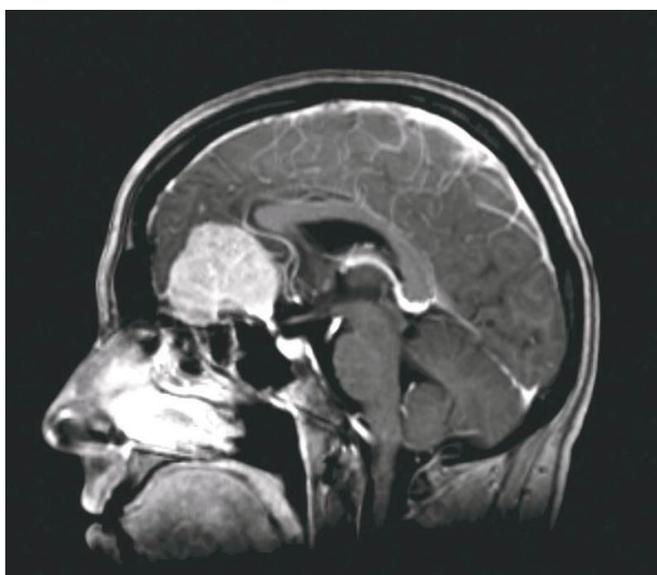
MRI image of Olfactory cleft meningioma
